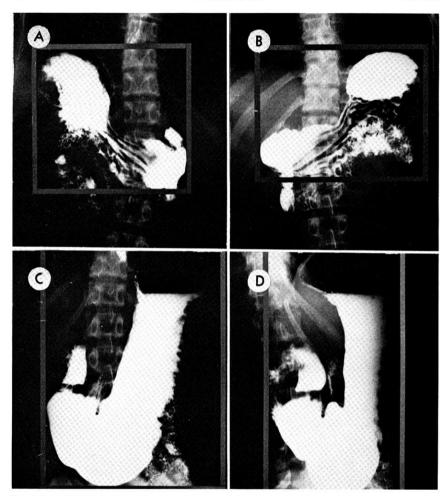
(A-D) The method of measurement of the size of a stomach including duodenal cap roentgenographed on a full size x-ray film in various positions.
